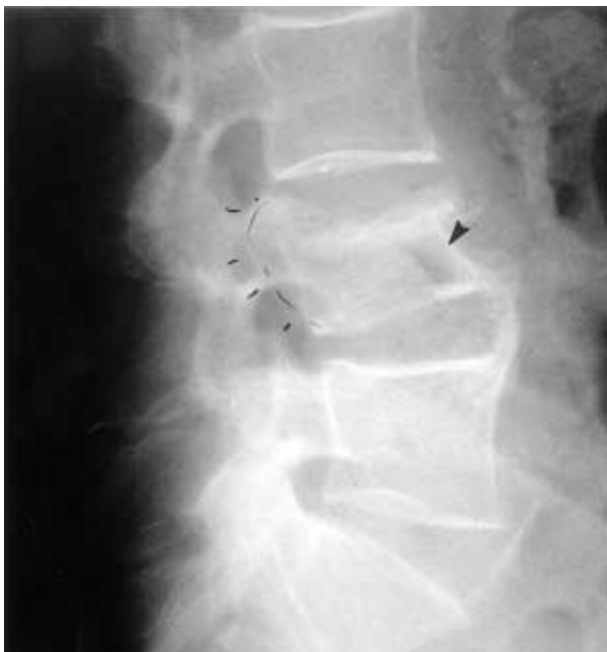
Lateral xray showing partial collapse of L4 vertebrae in a patient with Kummell's disease. See arrow pointing to intraosseous air.
